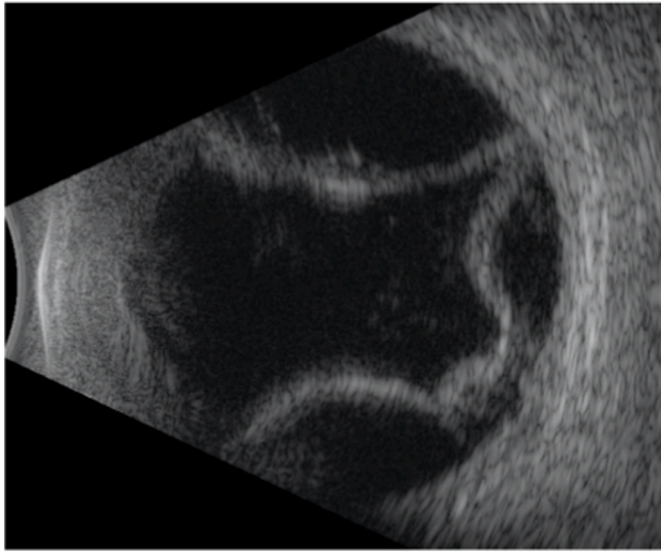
B-scan ultrasound of the right eye from initial visit. T6E view showing large, serous choroidal detachment.
